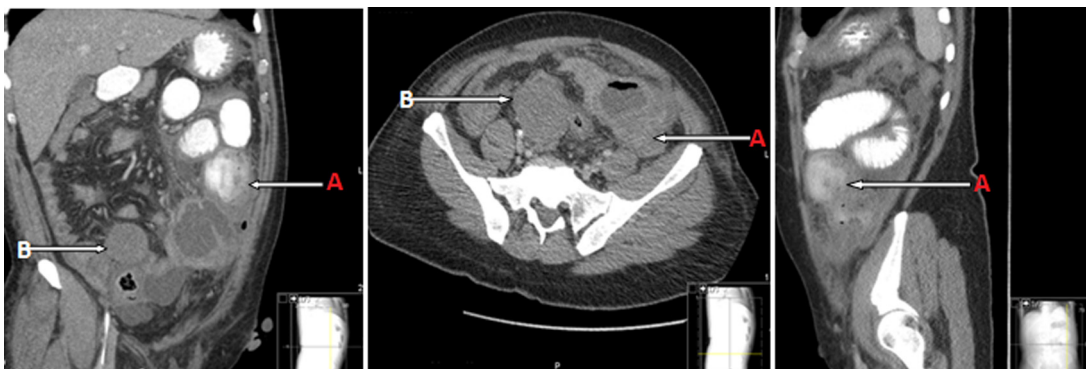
Sections from computed tomography scan with oral and intravenous contrast enhancement demonstrating the locations of the two intra-abdominal desmoid tumours indicated by the arrows. Arrows “A” demonstrate the distal jejunal lesion and arrows “B” show the lesion in the ileocaecal region.
